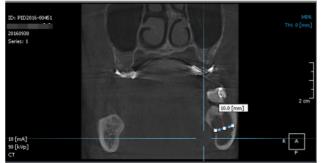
CBCT scan, the visualization of a cyst, its dimensions and relations with the vestibular and lingual cortical bone, measuring $10\,\text{mm}$
